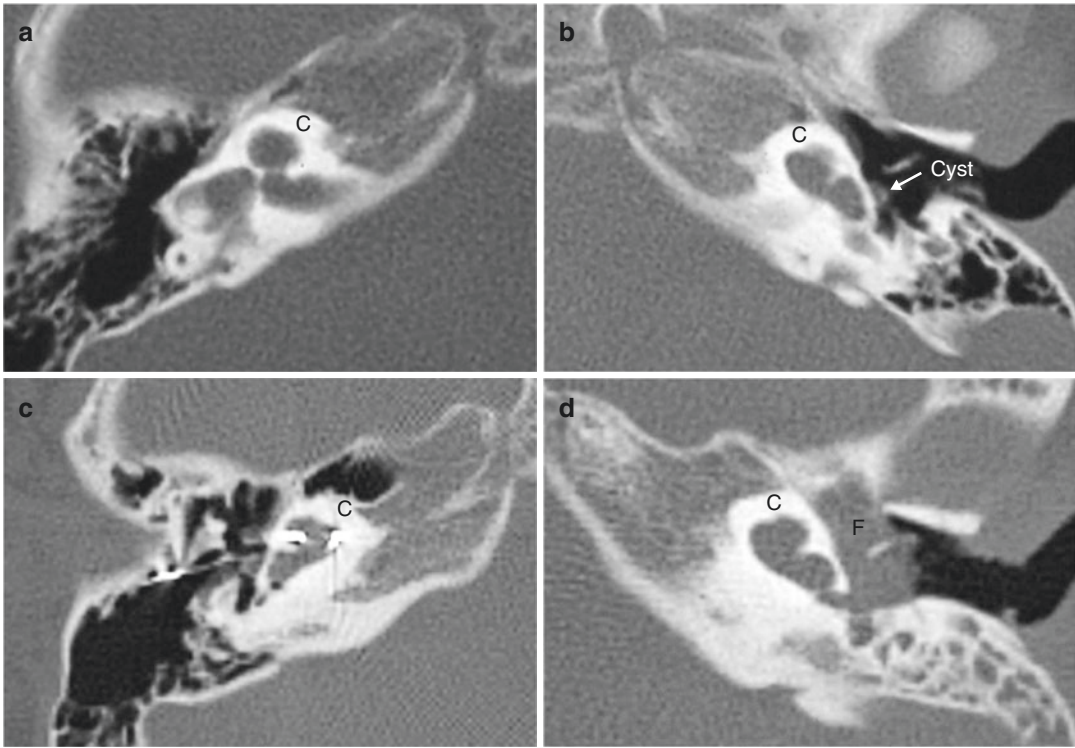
Case 3 bilateral IP-I deformity (a = Right and b = Left) with no fluid in the middle ear and mastoid. Please note the soft tissue mass (cyst) on the left side which was noticed postoperatively. (c) HRCT showing
